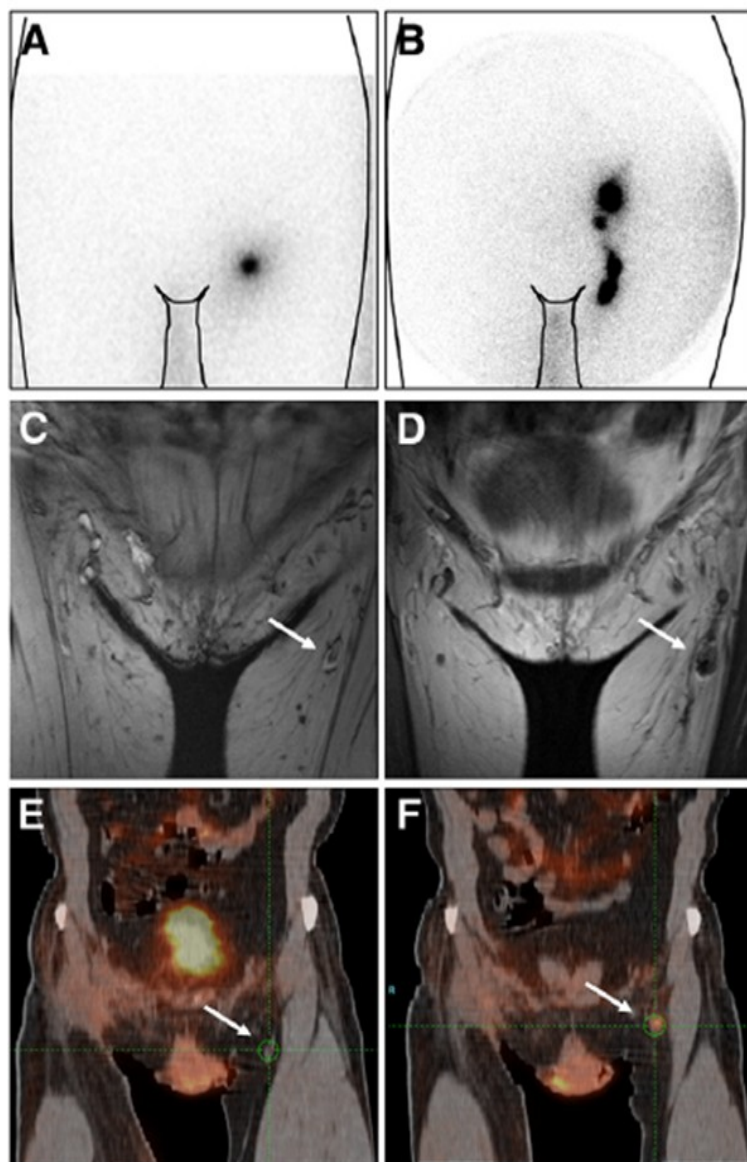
Examples of *in vivo* imaging of cellular therapy in clinical studies. Different modalities can be used to track pre-labeled dendritic cells after injection, or to image their effect on the local immune system. For example, phagocytic DC can be labelled with $^{111}\text{Indium}$ oxinate and visualized by scintigraphy directly after injection in the lymph node (A) and even 48 hours later (B). Distribution or spreading over a number of secondary lymph nodes indicates active migration to secondary lymphoid organs and the number of dendritic cells per spot can be calculated as percentage of total injected cells. In contrast to scintigraphy, MRI has excellent soft tissue contrast with highly detailed anatomical information. Here, DC were labelled with SPIO and injected i.n. in the same patient as (B), following scintigraphy, MRI scanning was performed directly after injection (C) and 48 hours later (D). MRI allows determination of the exact location of injected cells, e.g. in a lymph node or fatty tissue, and to an exact number of lymph nodes (1). In another patient, the metabolic activity of the target lymph node before (E) and after (F) a series of i.n. DC vaccinations was investigated using ^{18}F -FDG PET. An increase in glucose metabolism indicates activated lymphocytes, resulting from interaction with transplanted dendritic cells.
